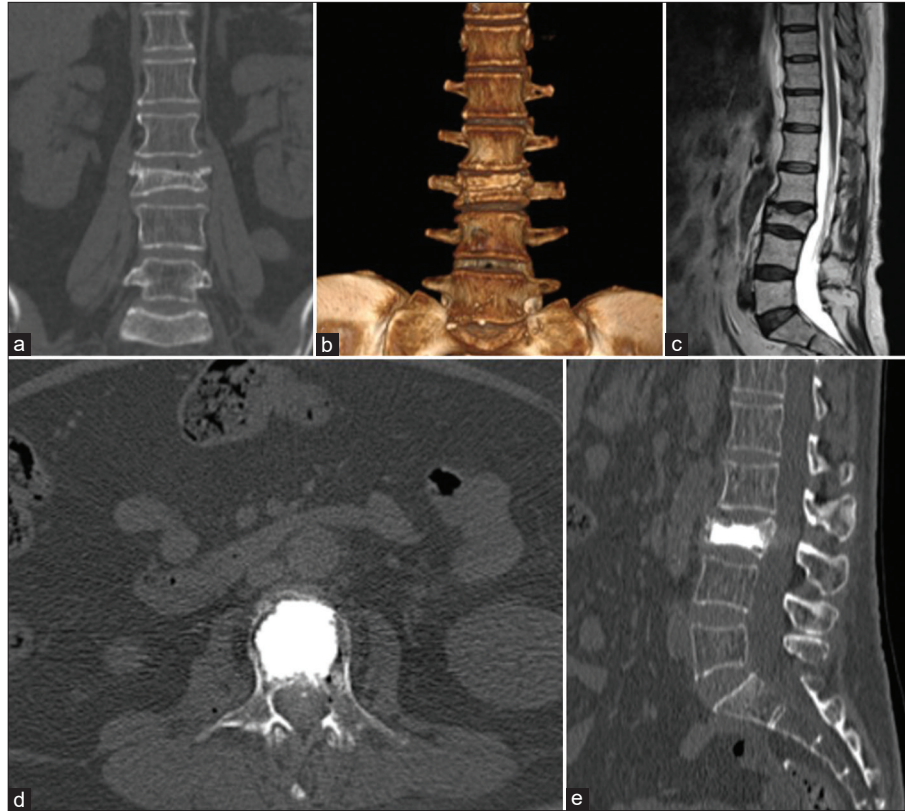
Lumbar tomography in coronal view (a) and 3D reconstruction (b), lumbar MRI in T2 weighting (c), where a L3 vertebral compression fracture is observed. Lumbar tomography in axial (d) and sagittal (e) view after kyphoplasty, with the presence of hyperdensity in the body of L3 corresponding to cementation.
